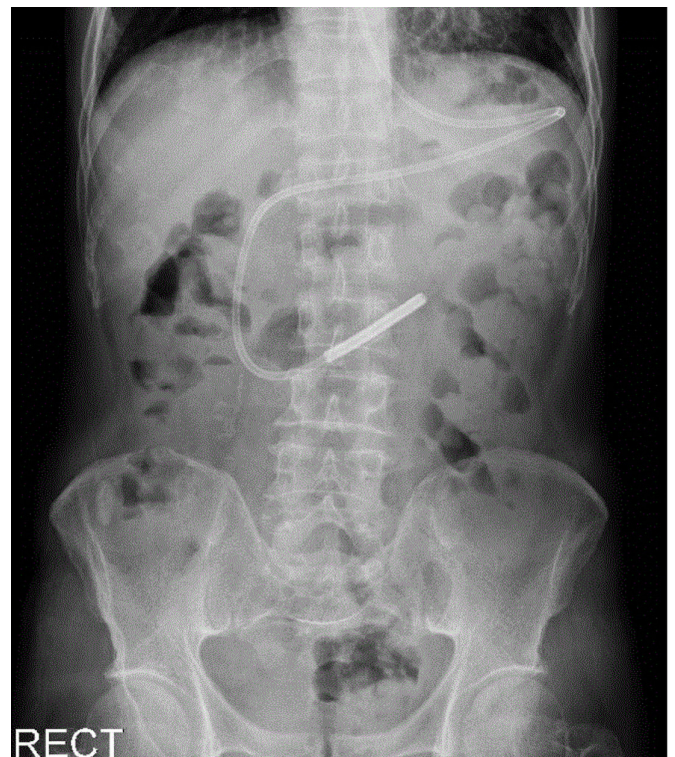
The erect view of the abdominal X-ray. A jejunum feeding tube was placed distally to the duodenojejunal junction.
